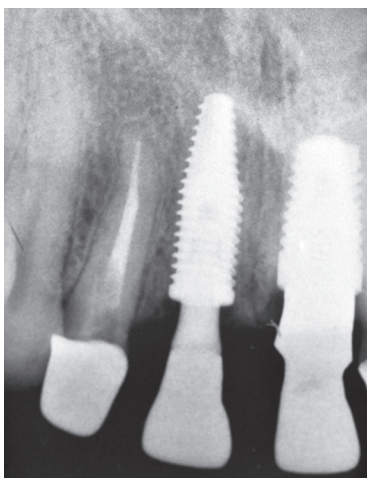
Radiograph showing the metallic infrastructures
